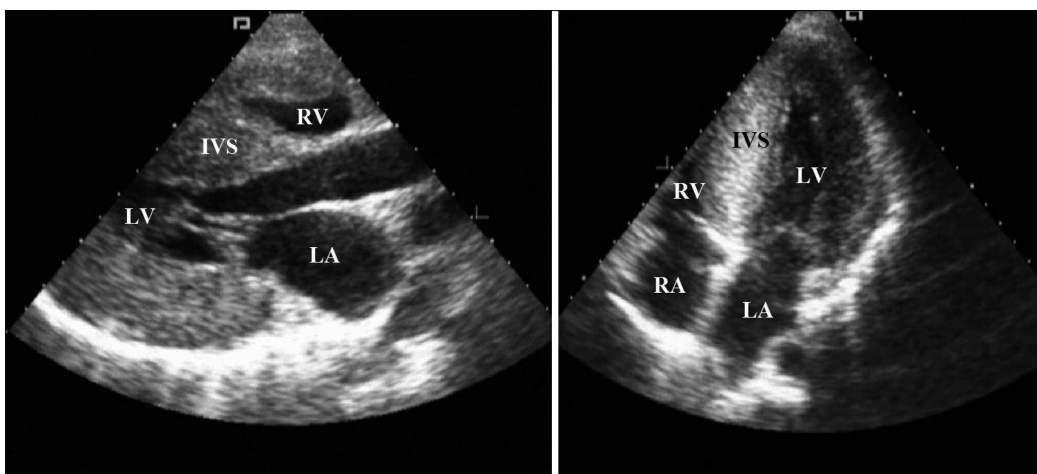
Parasternal large axis view (left) and apical four-chamber view (right) depicting global thickened of the left ventricular walls and right ventricle and interatrial septum involvement. IVS: interventricular septum; LA: left atria; LV: Left ventricle; RA: right atria; RV: right ventricle
